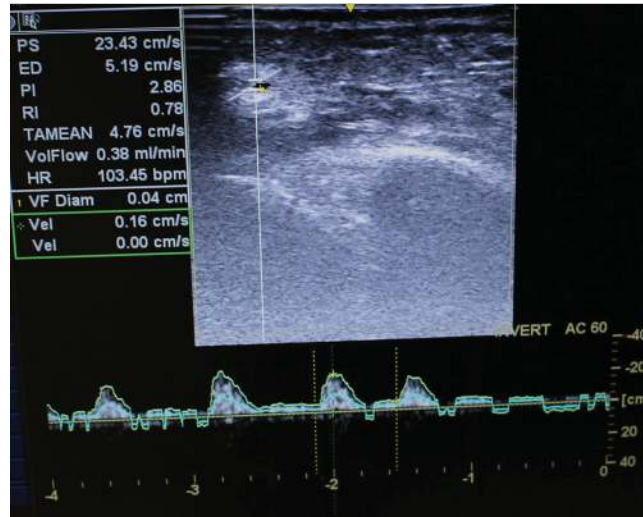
Color Doppler. The size of the vessel and the flow velocity of the vessels can be checked.
